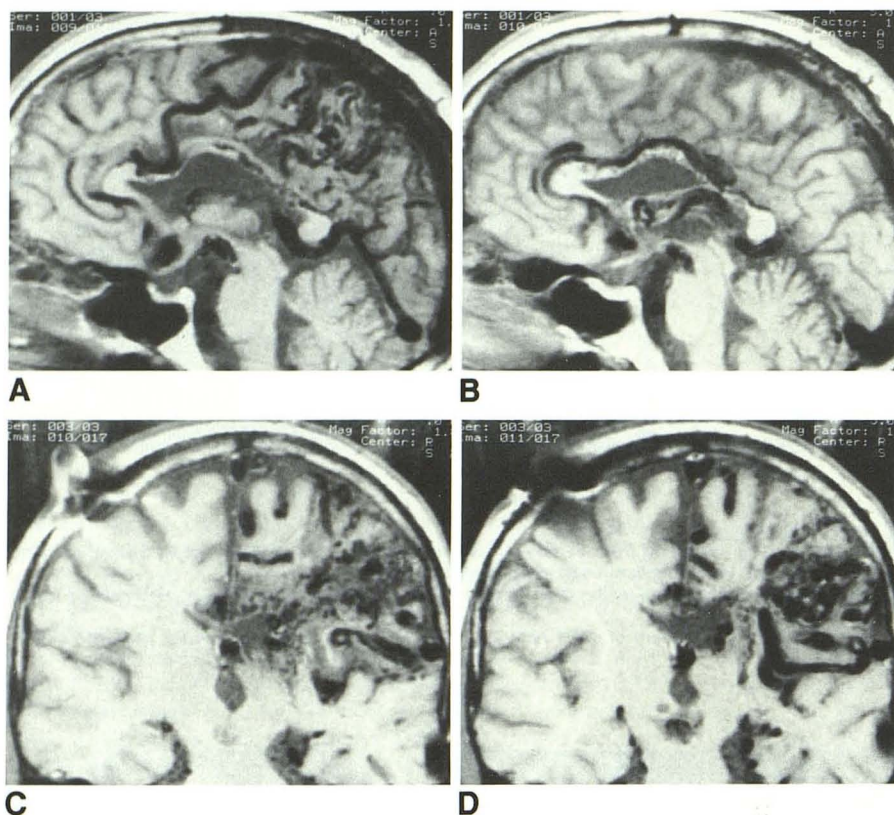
Replacement of part of corpus callosum by large left parietal AVM. Sagittal (A and B) and coronal (C and D) MR images (TR 600, TE 20). Note near total replacement by AVM of posterior half of the body of corpus callosum and marked thinning also of anterior half, which is penetrated by numerous small vessels. Large arterial feeders (anterior and middle cerebral) as well as large draining veins (internal cerebral and cortical) are also seen. The distortion and signal void in right parietal bone are due to a burr hole and a shunt.
